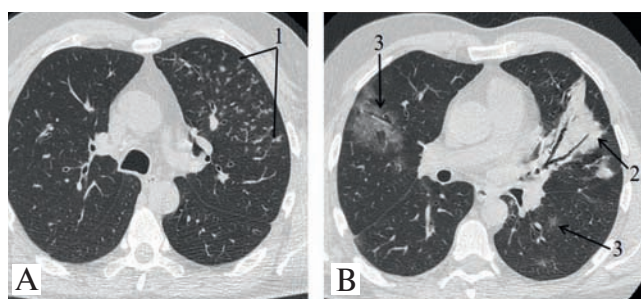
Patient A. 48 years. Moderate COVID-19, complicated by bacterial superinfection. Computed tomography, axial slices, 14th day of the disease. Bronchopneumonia features: tree-in-bud sign (1) in the upper left lobe, segmental consolidation with air bronchogram (2). COVID-19 features: bilateral round-shaped foci of ground glass (3)
